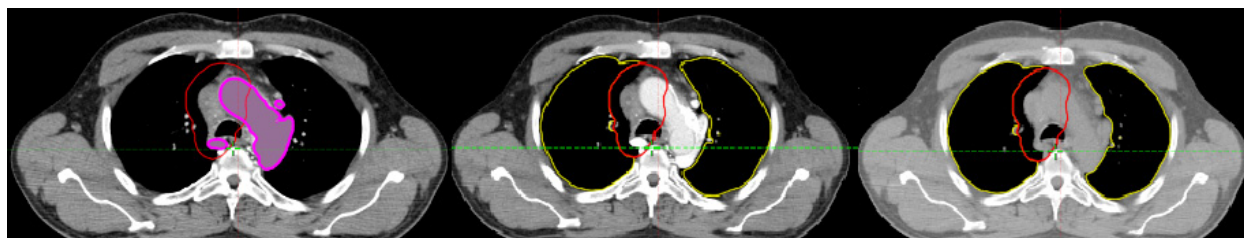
Right: contrast-less. Center: contrast-enhanced. Left: Modified contrast-enhanced CT scan
